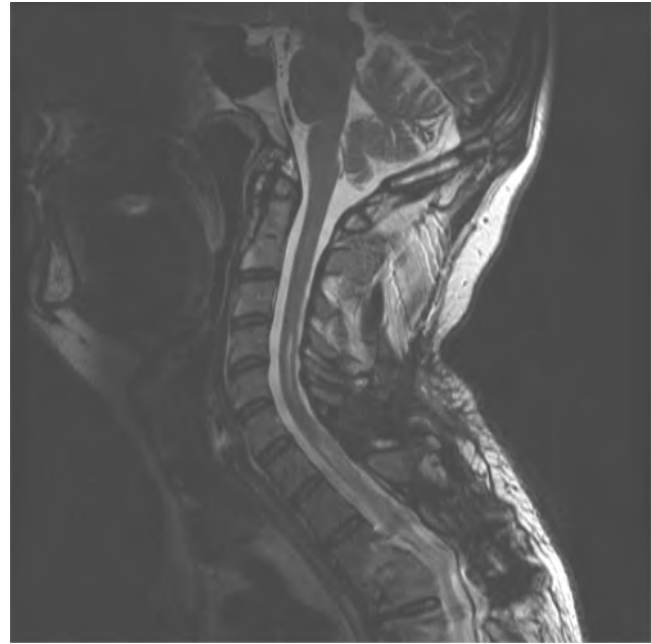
Syringomyelia. Imaging of patient whose scan is shown in Figure 15.8 following insertion of syringopleural shunt resulting in successful syrinx decompression (MRI T2W).
